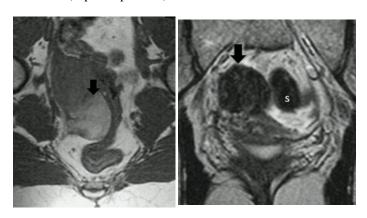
Pelvic MRI (left image-T1w axial, right image-T2w coronal) demonstrating the extrauterine mass (black arrows) adjacent to the sigmoid (s) colon. The mass has a fetal shape and contains fetal structures (cephalic position).
